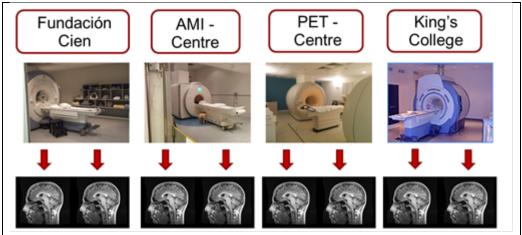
Harmonisation of MRI/DTI data across the four study centres.
